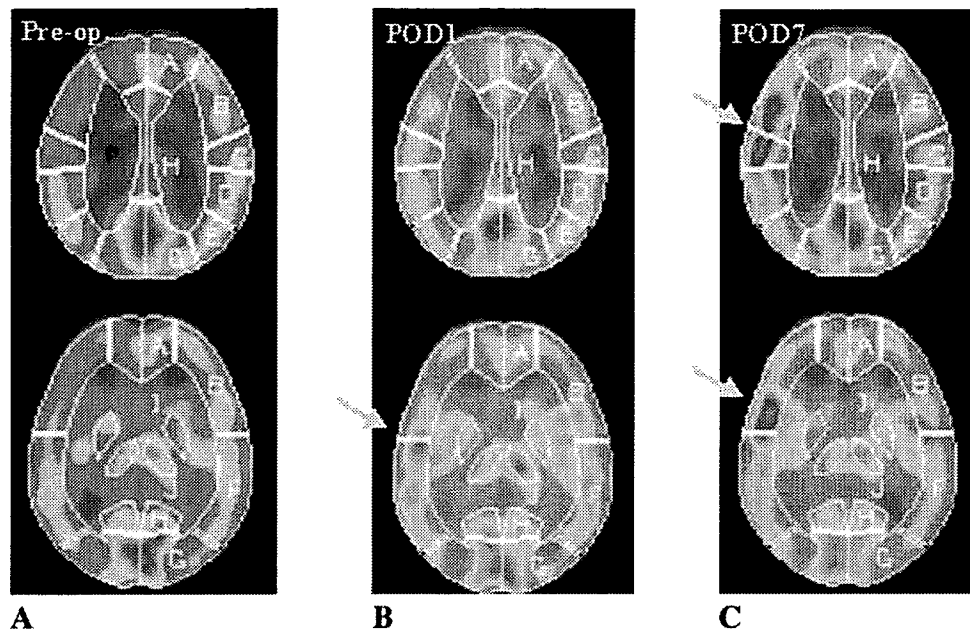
Case 6. ^{123}I -IMP-SPECT scans before surgery (A) and 1 (B) and 7 days (C) after surgery. Mild increase in CBF was detected at the site of anastomosis 1 day after surgery (arrow in B). The focal intense increase in CBF at the site of anastomosis (arrows in C) was evident 7 days after surgery, in accordance with the manifestation of dysarthria and sensory disturbance on the left hand.
